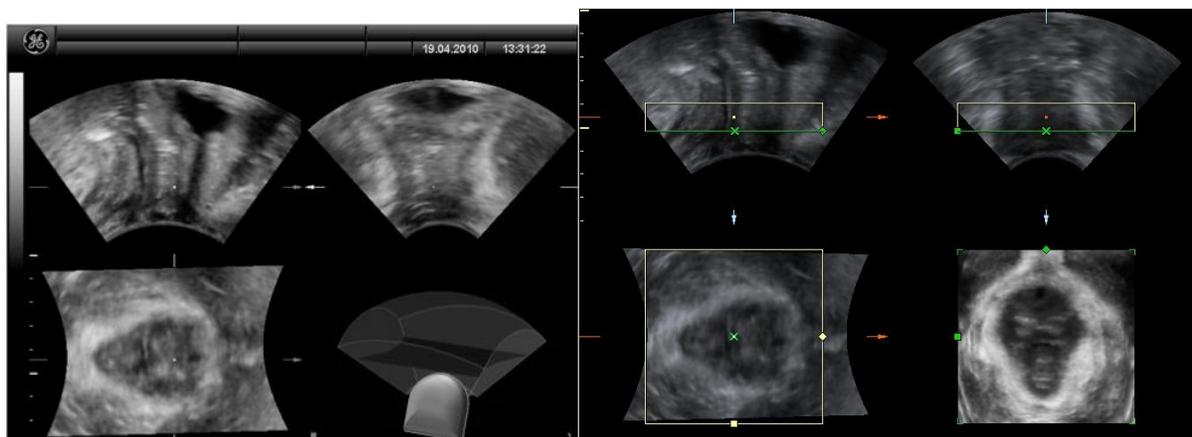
Levator ani muscle assessed with 3D ultrasound
